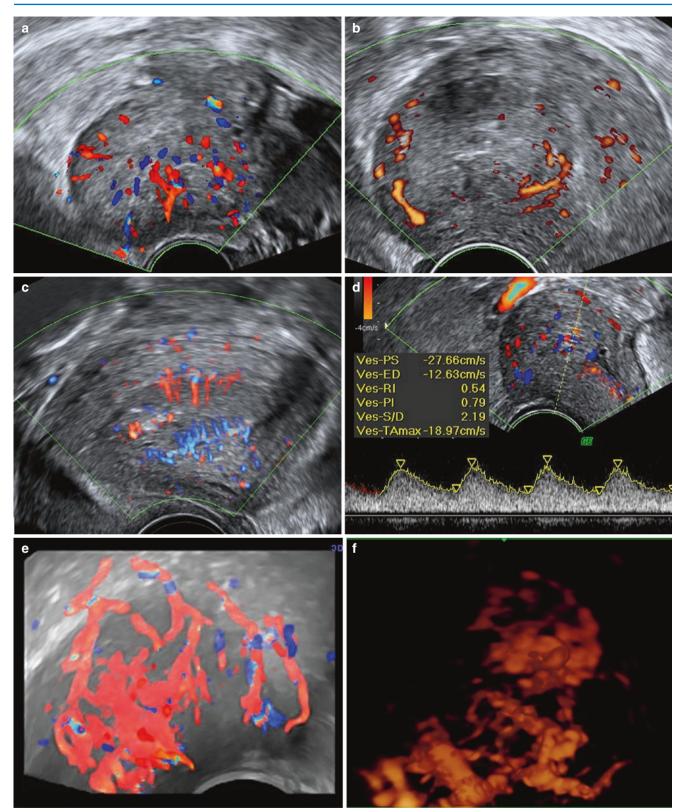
Various types of Dopplers: (a) Colour Doppler; (b) Power Doppler; (c) High-definition Doppler; (d) Pulse wave or spectral Doppler; (e) 3D colour Doppler with glass body display mode (showing greyscale image of the tissue studied in background); (f) 3D power Doppler with angio display mode (the vascular tree morphology is seen, but greyscale tissue display to correlate is absent); (g) Volume histogram for flow indices (VI, FI, VFI)
